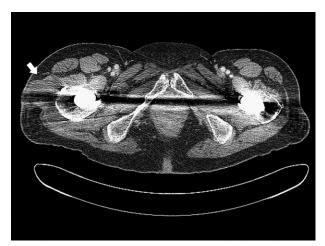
Bursitis of the right greater trochanter was seen on axial view of the hip CT (arrow).
